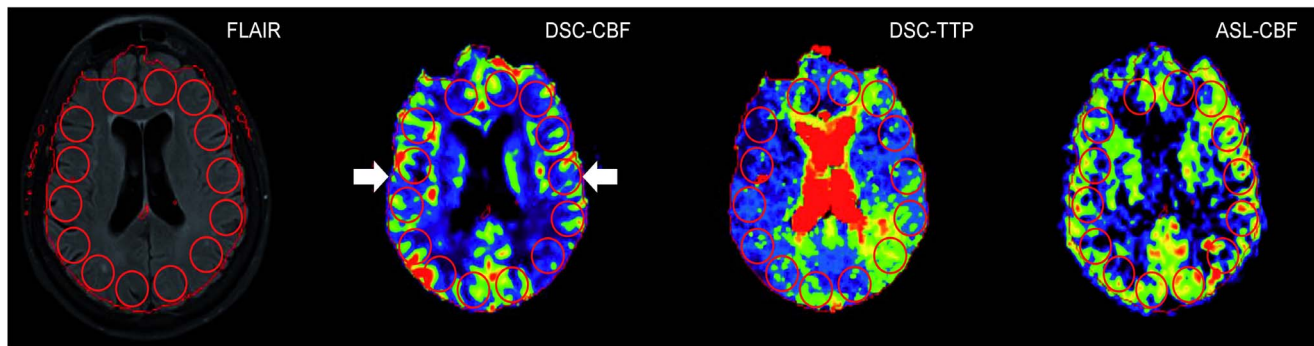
Quantitative analysis of DSC-CBF, DSC-TTP and ASL-reICBF. 20 mm circular regions of interest (ROIs) were placed on the FLAIR image and copied onto coregistered DSC-CBF, DSC-TTP and ASL images. For relative values, the ratio of each ipsilateral ROI to the arithmetic mean of all contralateral ROIs was calculated. In case of DSC-TTP the values were subtracted to obtain relative TTP-delay. DSC-perfusion maps were automatically masked by the used software. Therefore, the contour of DSC maps was used to define the cortical rim (contour, arrows).
